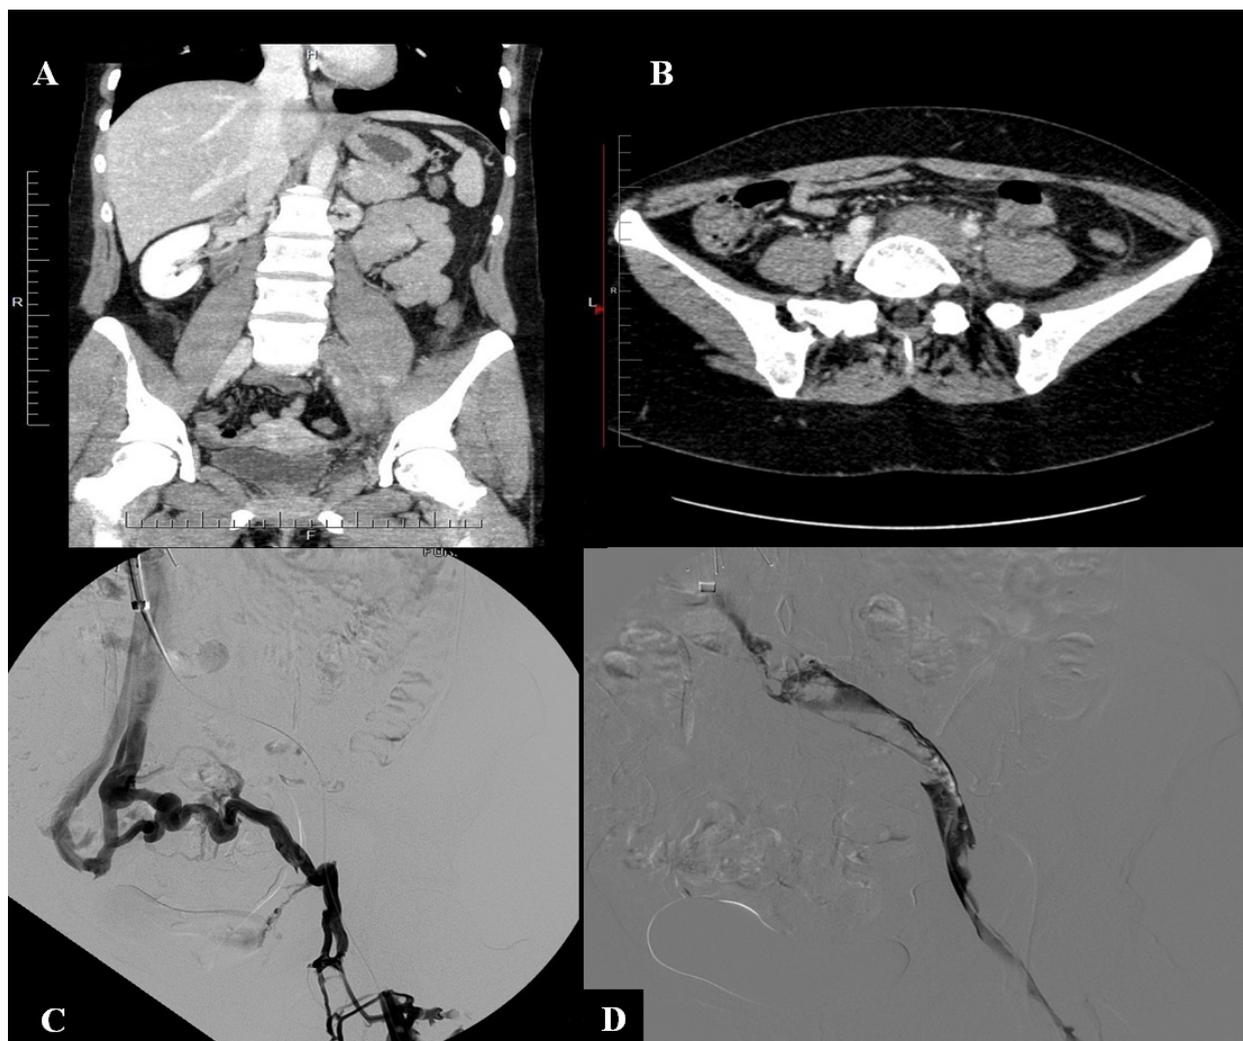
A: CT scan shows compression and thrombosis of left common iliac vein by right common iliac artery. Permeable flow can be seen in the right common iliac vein; B: venogram revealing thrombosis of the left iliofemoral venous system and the presence venous collateral flow from the left common femoral vein to the right hypogastric vein; C-D: pharmacomechanical thrombolysis. The thrombus was removed with an Arrow Trerotola PTD device and angioplasty. No stent was placed in this case. Subsequently, normal flow was restored
